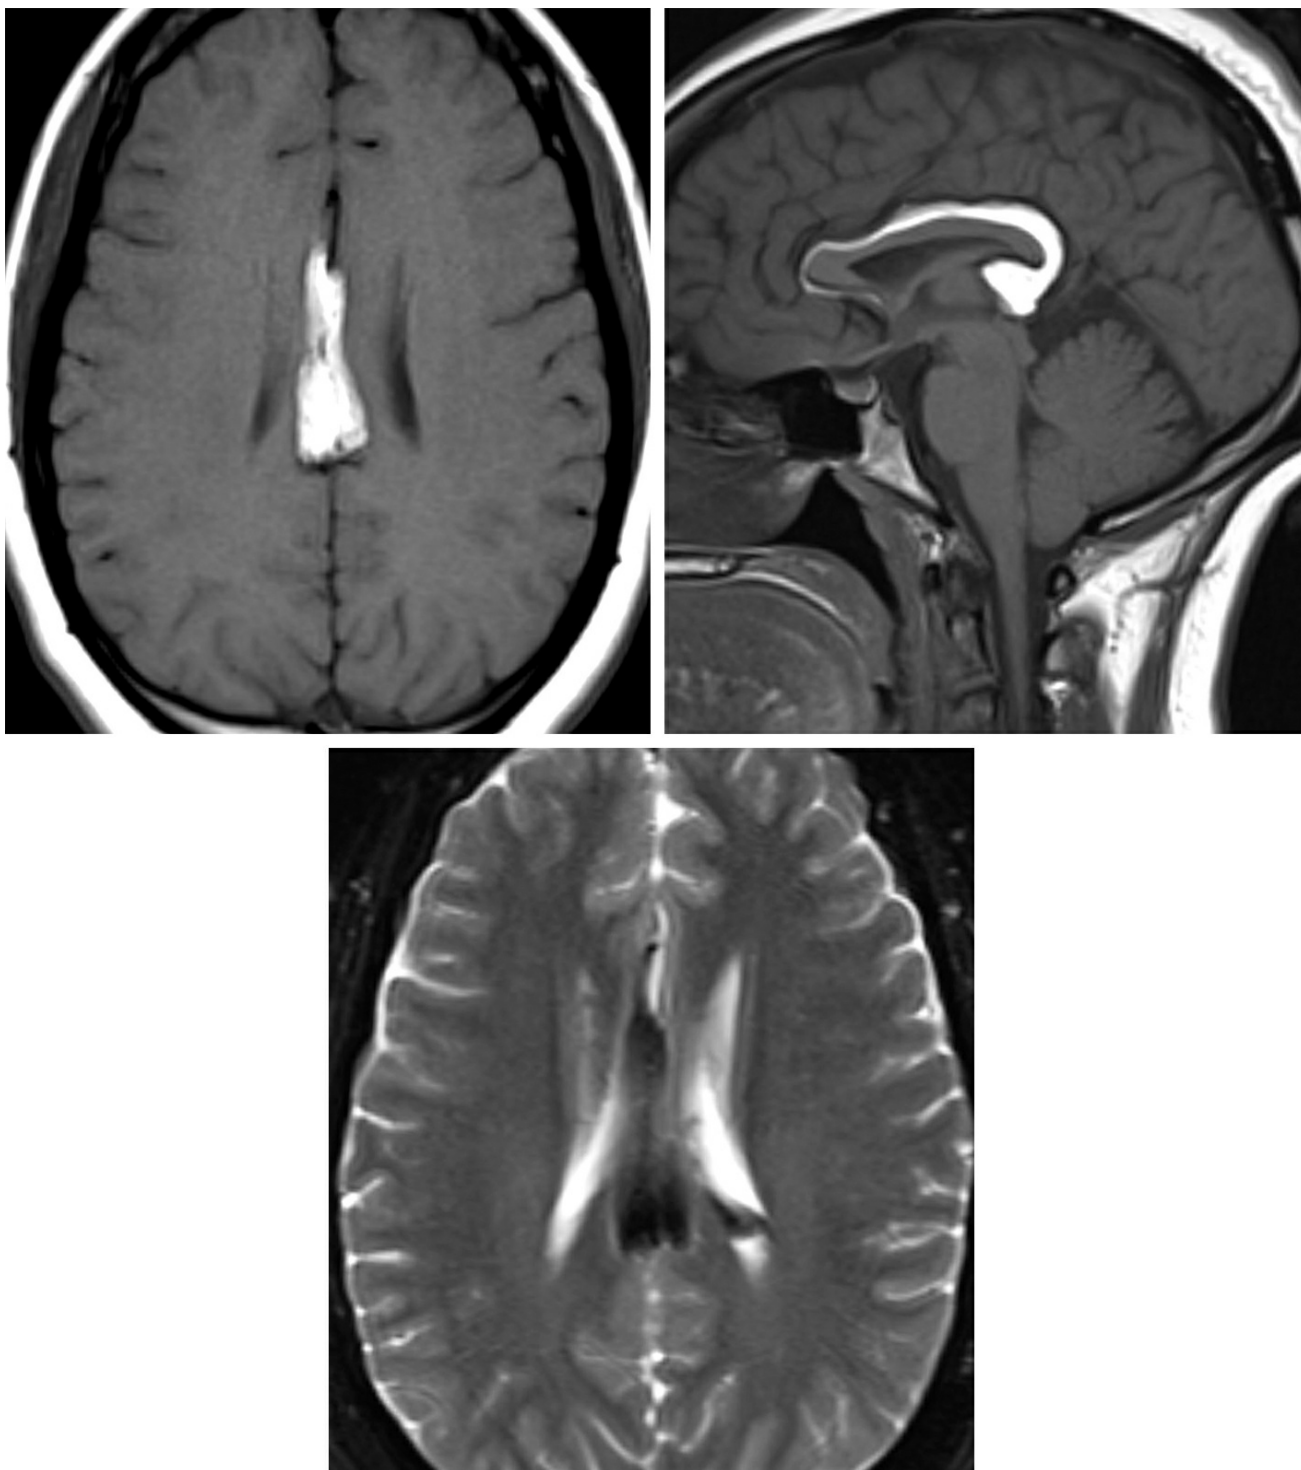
Axial (top left) and sagittal (top right) T1-weighted images demonstrate an intrinsically T1 hyperintense pericallosal mass that is suppressed on T2-weighted fat-saturation imaging (bottom). The appearance and location are classic for intracranial lipoma, resulting from a developmental failure of the meninx primitiva to involute.
